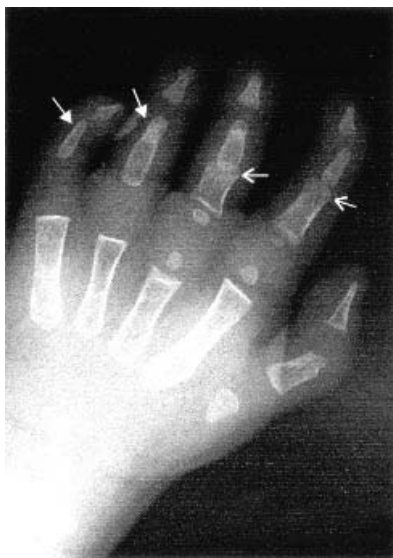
Proximal symphalangism. Radiograph of hand of a 3-months-old patient with conductive hearing loss and decreased mobility of proximal phalangeal joints showing complete bony fusion of the proximal interphalangeal joint of fingers IV and V (arrows), as well as hypoplastic joints and middle phalanges of fingers II and III (arrows). (Courtesy of P. Meinecke, Hamburg.)
